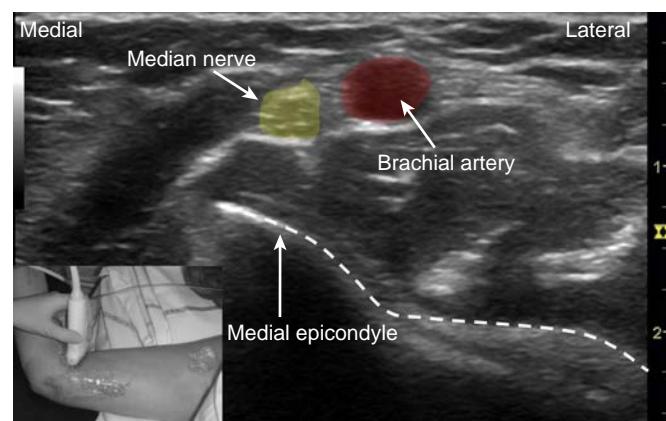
Ultrasound view of median nerve at the elbow level.
